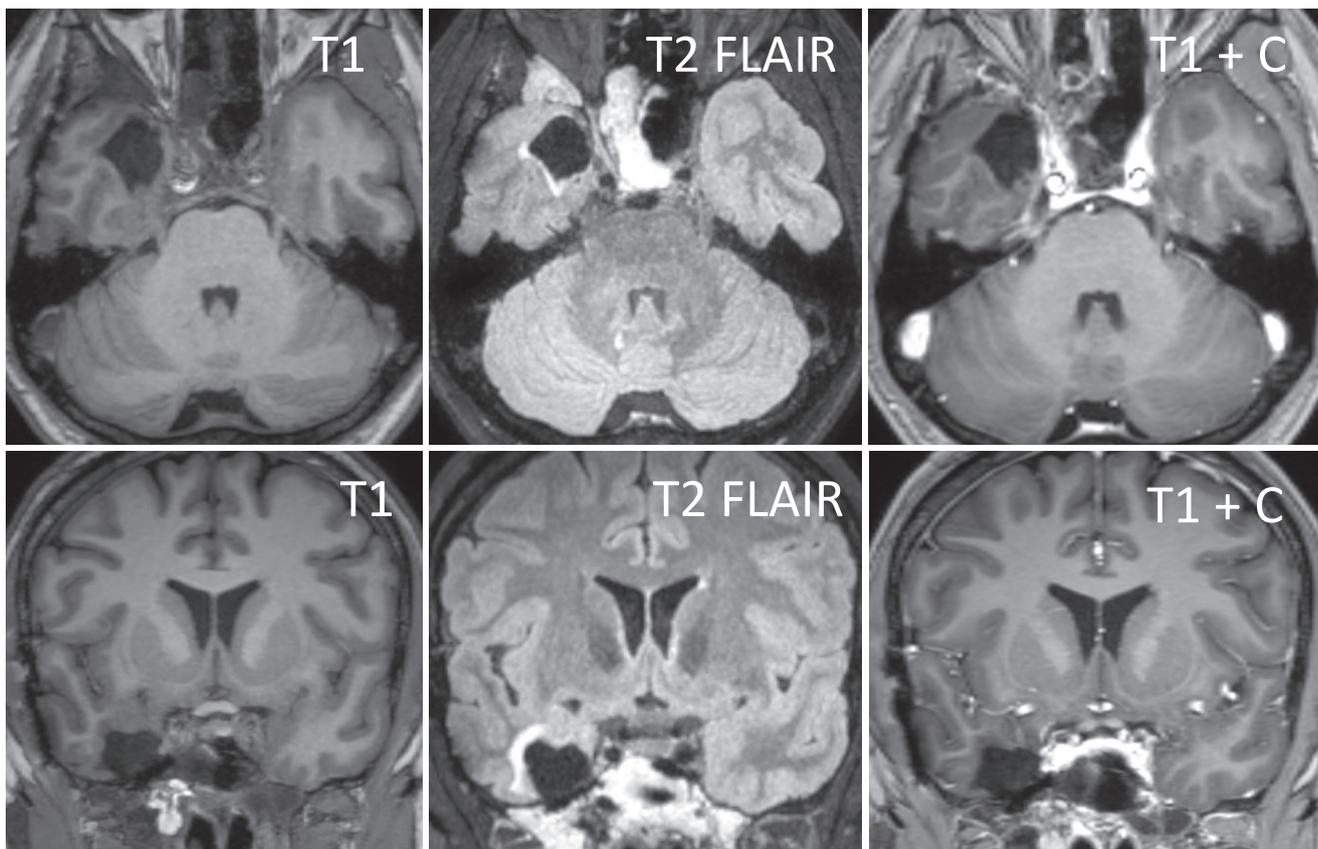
MRI obtained for presurgical workup, prior to the placement of RNS to the right hippocampus and right orbitofrontal area. Shown are axial and coronal T1, T2 FLAIR, and T1 post-contrast images demonstrated R temporal cavity consistent with prior right focal encephalocele resection.
